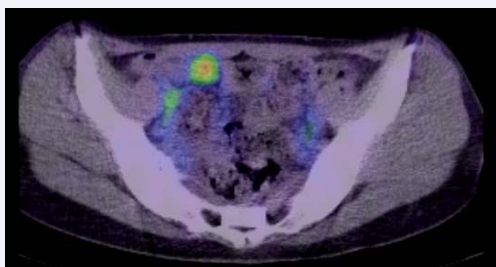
Axial fused SPECT/CT images verified that the focus of right hemiabdomen uptake was consistent with a Meckel's diverticulum.
